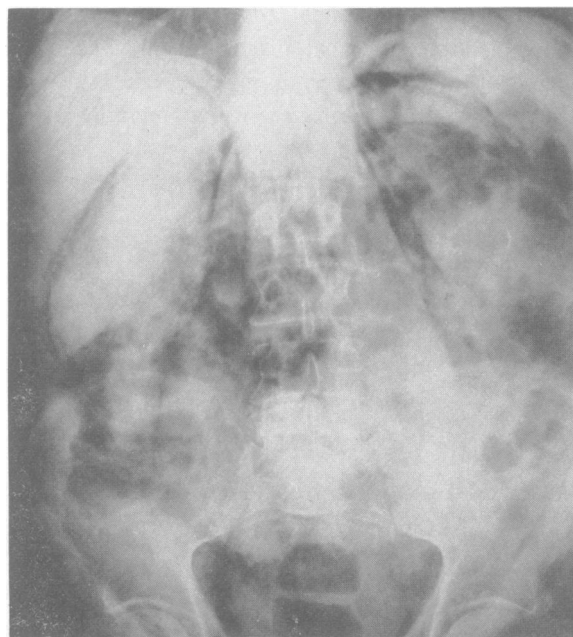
X-ray film of the abdomen (case 1) showing retroperitoneal air outlining both kidneys.
